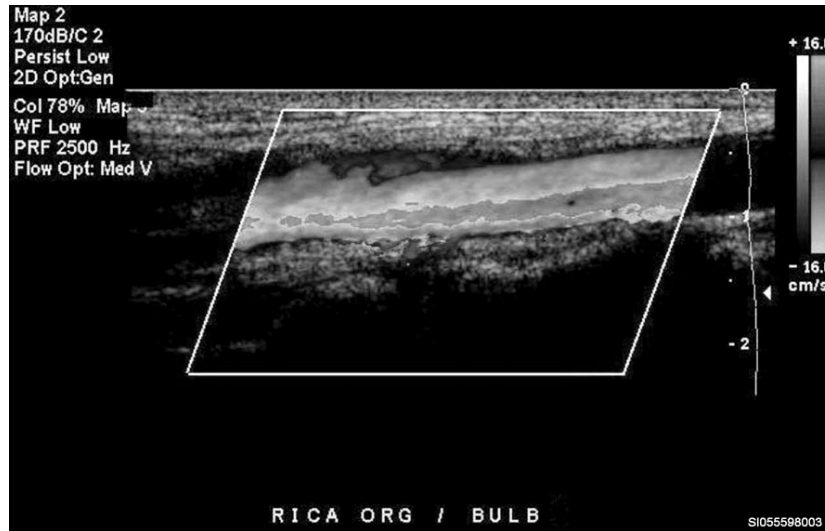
Doppler color box.
